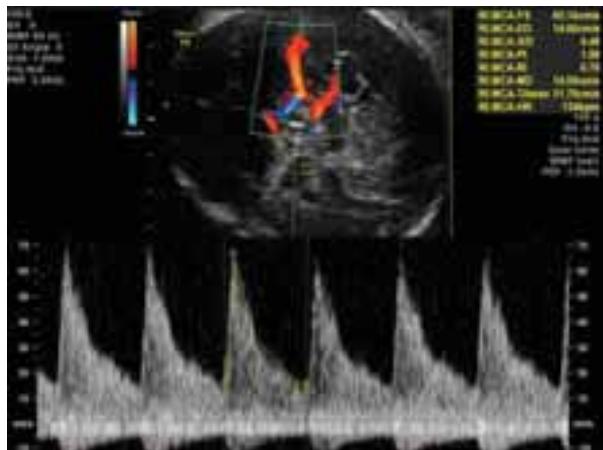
Doppler waveform of increased middle cerebral artery peak systolic velocity (MCA-PSV). (Photo courtesy: Mediscan Systems, Chennai.)
